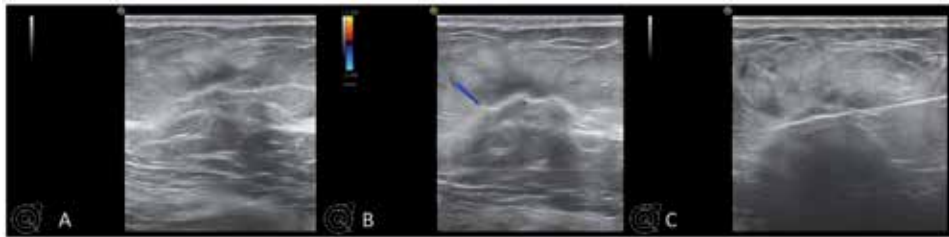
Hypoechoic area with hyperchoic halo resembling the picket fence sign (A), with minimal vascularization on color Doppler (B). The core needle biopsy (C) revealed an ILC lesion, with positive estrogen and progesterone receptors RE = 100%, RP = 25%, Ki67 = 15%, and HER2 negative.*
